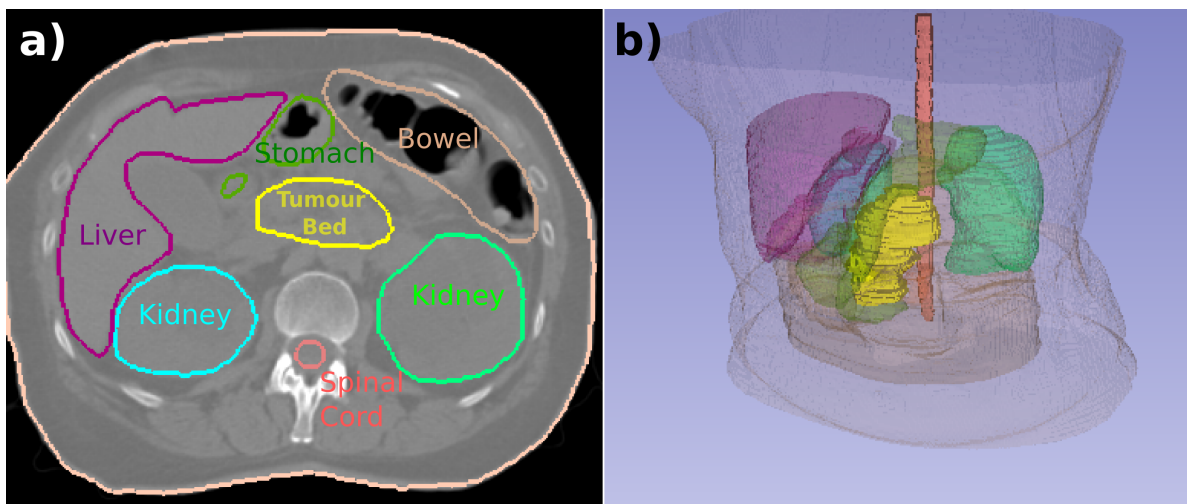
a) Transversal view of a computed tomography image of a pancreatic patient with the main surrounding organs delineated. b) 3D reconstruction of the patient anatomy.
